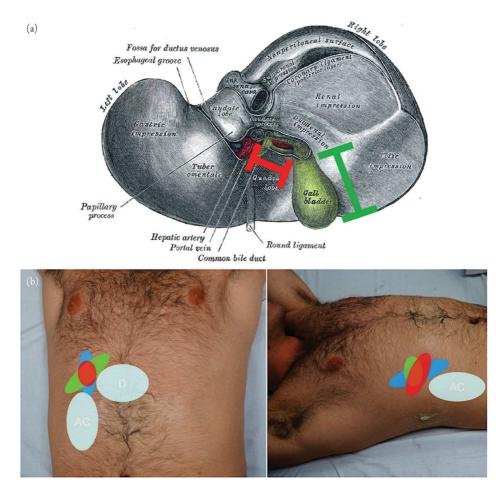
(a) Anatomy of gallbladder and mobility. This view of the liver is from a posterior-to-anterior vantage point. The gallbladder neck and infundibulum (indicated by red bars) lie in the gallbladder fossa, which is where the porta hepatitis and portal triad are also found. These structures are held together by the hepatoduodenal ligament, rendering the proximal gallbladder relatively less mobile. In contrast, the body and fundus (indicated by green bars) are surrounded by loose connective tissue of the visceral peritoneum, and are relatively more mobile. Adapted from Figure 1086 of Gray H. *Anatomy of the Human Body*. New York, NY: Lea & Febiger; 1918. (b) Variable position of gallbladder. The gallbladder is a highly mobile organ, with its positioning due to the anatomy of the gallbladder fossa in the liver, mass effect from adjacent duodenum (D) and ascending colon (AC), and patient positioning. There are, however, some common orientations to note. In blue, the gallbladder, from fundus to neck, is in an inferior-to-superior orientation. In green, it is in a lateral-to-medial orientation, and in red, it is largely anterior to posterior. Recognizing these common orientations will help the sonographer to develop a three dimensional sense of the gallbladder that is necessary for ultrasound imaging.
